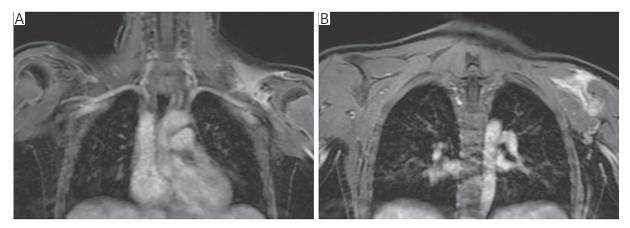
Bilateral shoulder MRI, Dixon/T1 water-only post-gadolinium images, coronal plane. Intense enhancement of the left clavicle and coracoid process of the left scapula (A), of the remaining affected parts of the scapula (B); intense enhancement of the surrounding soft tissues (A, B)
